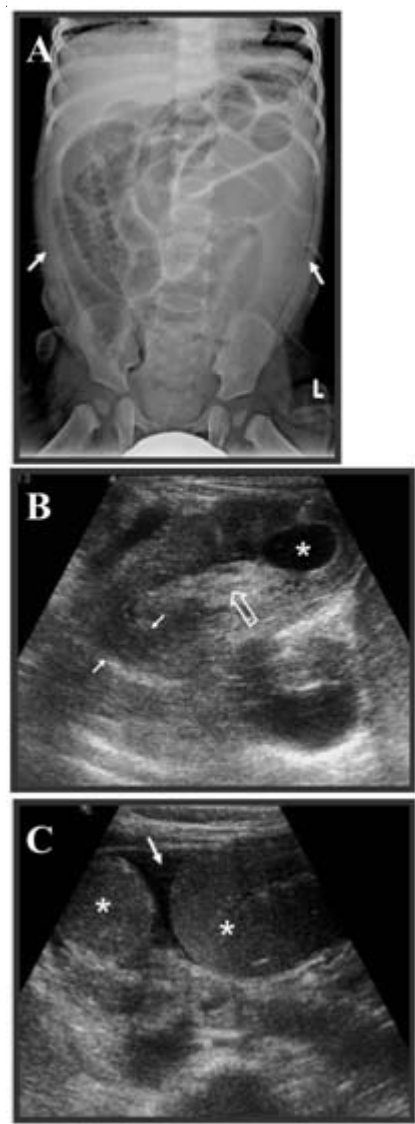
Radiographic and ultrasonic images in nine-month-old boy with vomiting and diarrhea with rectal bleeding. Pneumatic reduction failed after three attempts. Operative finding found irreducible ileo-colic type of intussusception with gangrenous ileal segment. No pathologic leading point was observed. A: Plain abdominal radiography showed multiple dilated small bowel loops and possible ascites (arrows). B: Ultrasonund showed intussusception up to descending colon with trapped fluid between intussusceptum and intussusciplen (*). Open arrow indicates internal hyperechogenicity that is invaginated mesenteric fat of intussusceptum, and thin arrow indicates colonic wall of intussusciplen with mild thickening. C: Evidence of small bowel obstruction (*) and small ascites (arrow).
